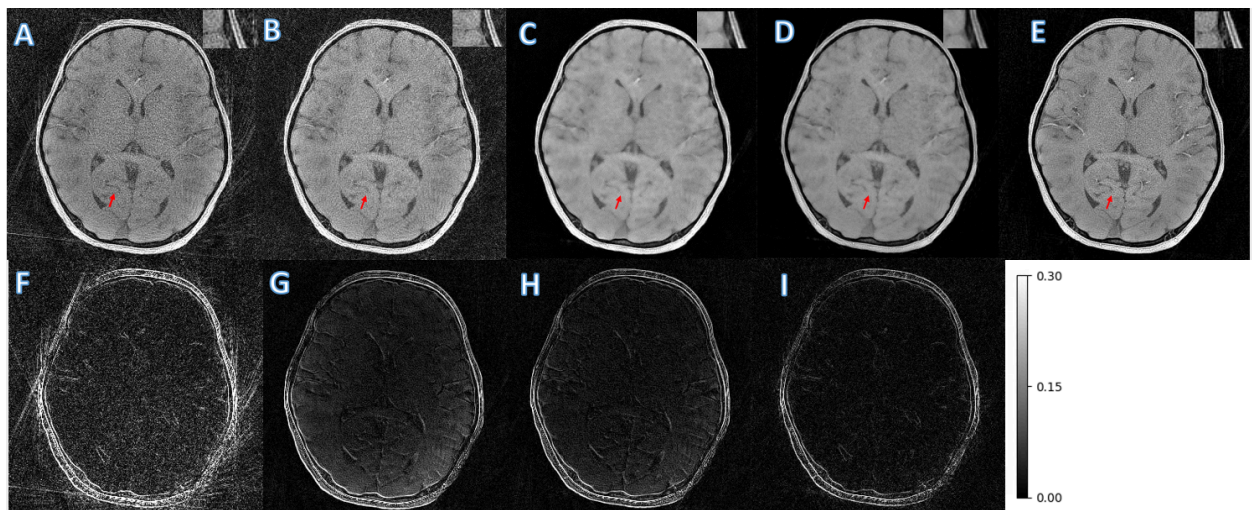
MR images 1 min MCNUFFT (A) , 1 min SSDU (B), 1 min un-wkDeLo (C), 1 min wkDeLo (D), and 5 min MCNUFFT reconstruction for 5.6 years old trauma patient, and the corresponding difference images ( $|1 \text{ min MCNUFFT} - 5 \text{ min MCNUFFT}|$ ) (F), ( $|1 \text{ min SSDU} - 5 \text{ min MCNUFFT}|$ ) (G), and ( $|1 \text{ min un-wkDeLo} - 5 \text{ min MCNUFFT}|$ ) (H), ( $|1 \text{ min wkDeLo} - 5 \text{ min MCNUFFT}|$ ) (I). The difference is  $\times 10$  times.
